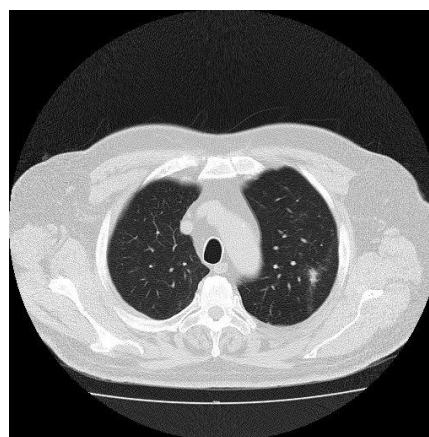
Computed tomography scan of thorax (08/2019): regression in size of left upper lobe tumor to 13 × 21 mm, almost complete regression of tree-in-bud micronodular lesions and infiltrative-atelectasis lesions in middle lobe of right lung.
